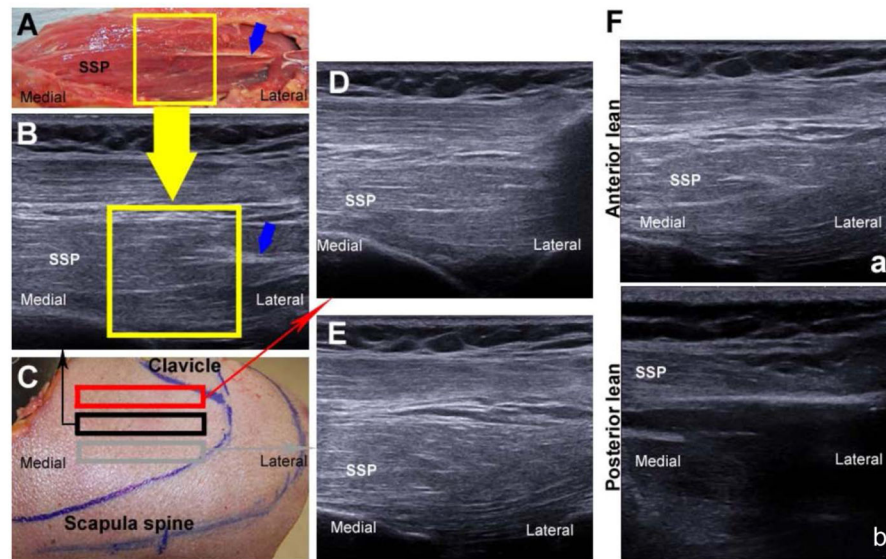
(Blue arrow: intramuscular tendon) A: Gross anatomy (coronal section) of right supraspinatus muscle, posterior view (Yellow box: center of supraspinatus muscle, and the same region as ultrasound image of B). B: Ultrasound image on which intramuscular tendon was observed when the probe was, perpendicularly to skin, positioned on the middle of the spine of scapula in mediolateral direction, and between clavicle and scapula spine in anteroposterior direction. C: Right cadaveric shoulder, superior view. Black box means the probe positioning where intramuscular tendon was observed when the probe was, perpendicularly to skin, positioned on the middle of the spine of scapula in mediolateral direction, and between clavicle and scapula spine in anteroposterior direction (Position A). Red and gray boxes show the probe positioning 1 cm anterior and posterior from black box (Position A), respectively. D: Ultrasound image on 1 cm anterior. The intramuscular tendon disappeared. E: Ultrasound image on 1 cm posterior. The intramuscular tendon disappeared. F: When the probe was inclined by more than approximately 20° to anterior direction, or approximately 20° to posterior direction from Position A, the intramuscular tendon also vanished in all ultrasound images.
